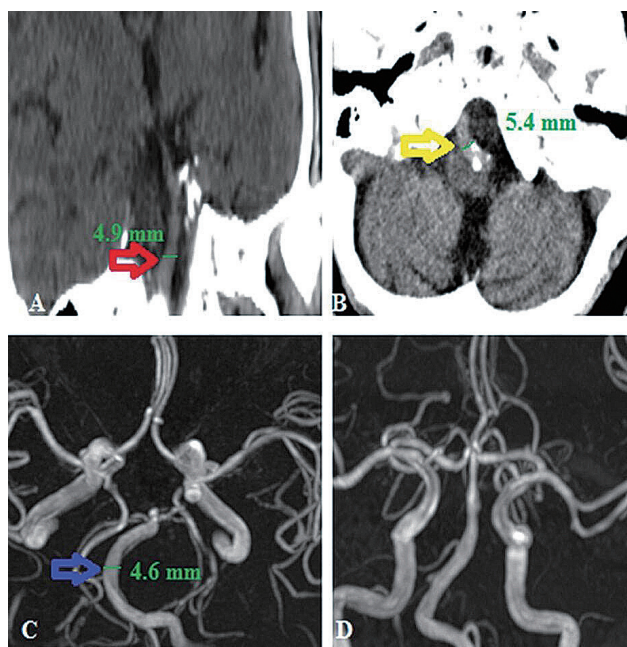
(A) Coronal CT shows tortuous basilar artery and its diameter as 4.9 mm (red arrow) and the basilar artery bifurcation extends to the base of the 3rd ventricle. (B) Axial CT shows an enlarged calcified vertebral artery indenting from the left into the medulla oblongata (diameter 5.4 mm-yellow arrow). (C) Basilar artery diameter of 4.6 mm at the pons level in the 3D-TOF MRA image (blue arrow). (D) 3D-TOF MRA Vertebral artery appears to be bent to the right.
